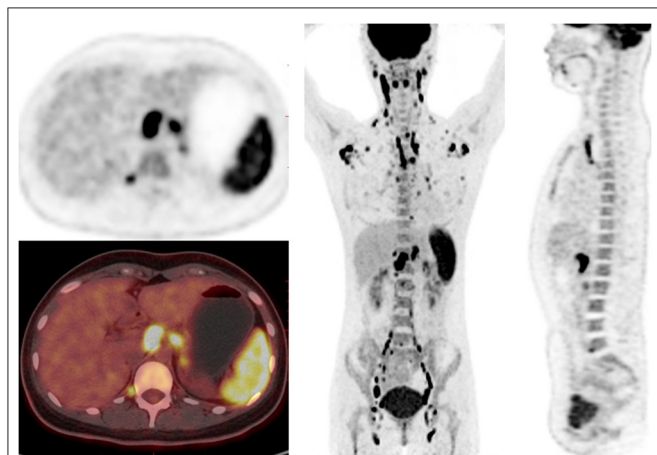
¹⁸F-FDG PET/CT images in a 23-year-old female of AOSD patient. PET/CT showed diffusely increased ¹⁸F-FDG uptake in spleen, bone marrow and lymph nodes, and reactive hyperplastic lymph nodes symmetrically distributed in the whole body.
